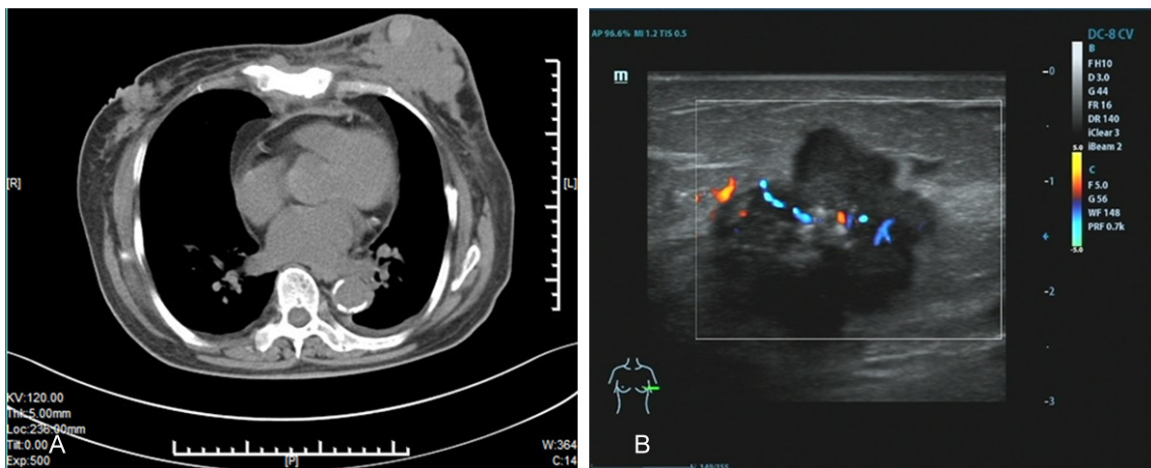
CT scan and Color Doppler ultrasound results. A: CT scan; B: Color Doppler ultrasound.
